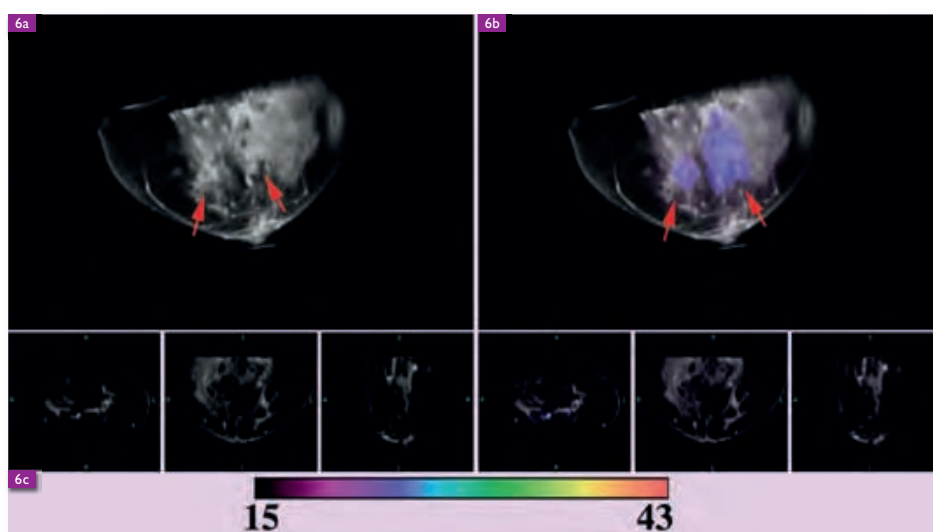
DCE MR images of the patient from Figure 5 taken within 48 hours after the second cycle of chemotherapy. It is difficult to discern here, but only two lesions enhance, indicating response to chemotherapy.
